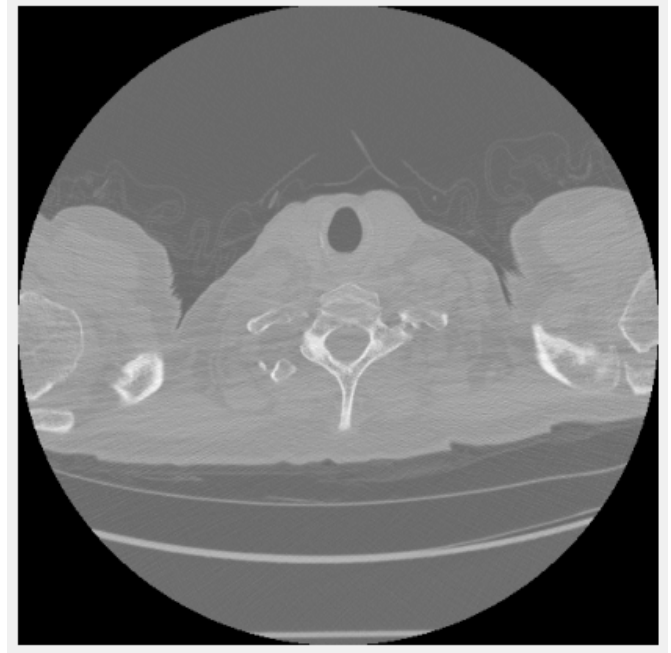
A CT Scan Image from the OSIC Cohort
